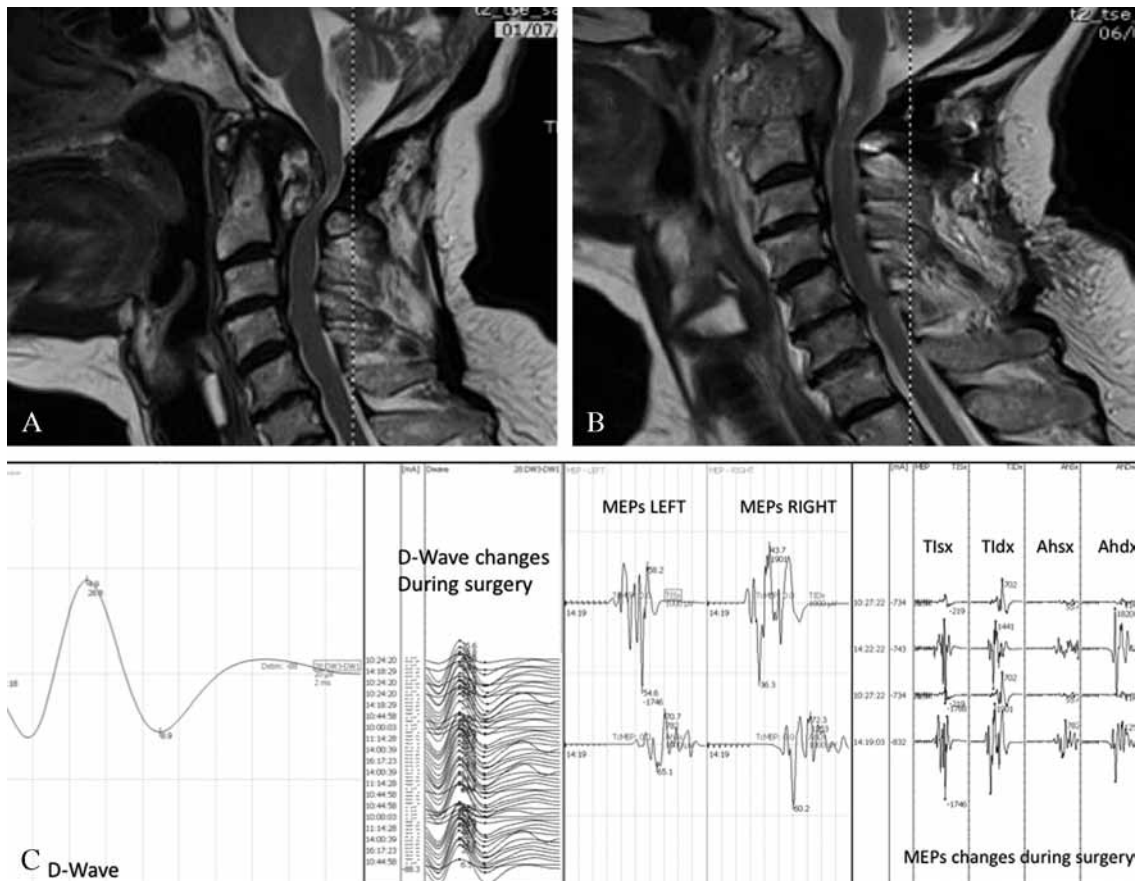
Preoperative (A) and postoperative (B) sagittal T2 MR images of a 77-year-old woman with a C1-C2 spinal cord tumour. The tumour was approached transorally, with gross-total removal, homologous bone graft positioning, and posterior C1-C2 fusion. Motor function monitoring (C) shows D-wave on the right side of the panel (at the end of surgery and variability during surgery), and muscle-MEPs on the left side, with lower arms in the upper part and upper arms in the lower part (at the end of surgery and variability during surgery). Muscle-MEPs showed amplitude variability during surgery in all four extremities, with a decrease up to 50% in the left arm, while D-wave amplitude variability always remained below 20%. No new motor deficit appeared postoperatively.
